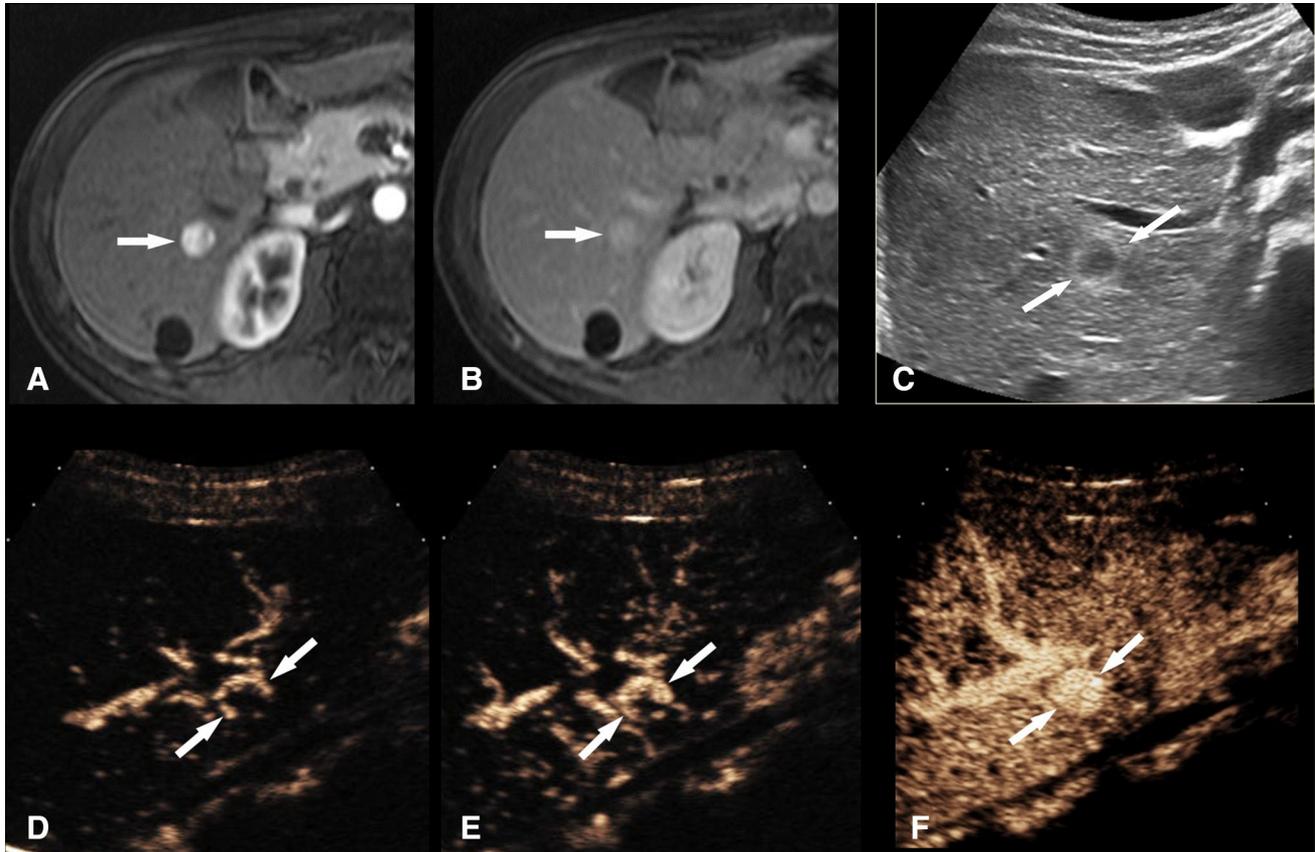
CEUS LR-1, a flash-filling hemangioma. A 59-year-old female with chronic HBV and a nodule on outside surveillance US. A Contrast-enhanced T1-weighted MR scan in the arterial phase shows a slightly heterogeneous hyper-enhancing nodule (*arrow*) in the liver. B The nodule (*arrow*) is homogeneously hyperintense in the delayed phase. MR findings are indeterminate as the arterial phase enhancement pattern is non-specific and there is no washout. C A greyscale US image confirms the right lobe focal liver nodule with an
